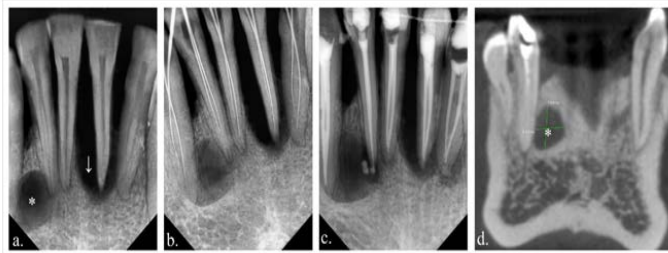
a. preoperative radiograph (*showing periapical cyst w.r.t #42,43 and down arrow showing severe vertical bone loss w.r.t #31), b. teeth showing multiple canals and working length determination, c. Obturation, d. CBCT image showing Periapical cyst in #42,43 measuring 7.9 x 5.9mm
